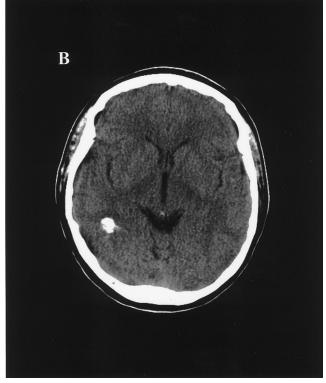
A, CT scan before empirical therapy for toxoplasmic encephalitis in an HIV-infected patient. B, CT scan 2.5 years later, after immune restoration with highly active antiretroviral therapy and 8 months without maintenance therapy for toxoplasmic encephalitis.
